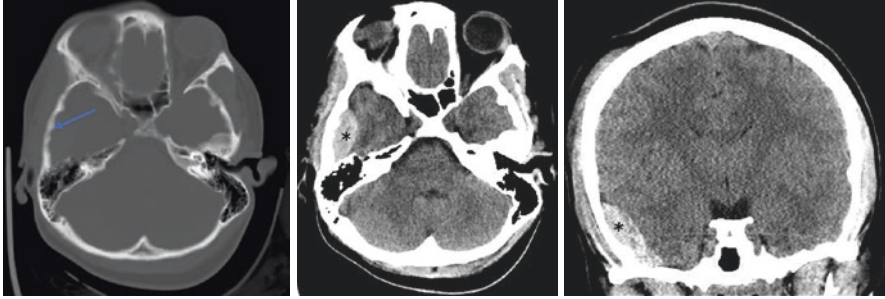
CT scan demonstrating a temporal skull fracture (arrow) with middle meningeal artery tear causing an acute epidural hematoma (*)
